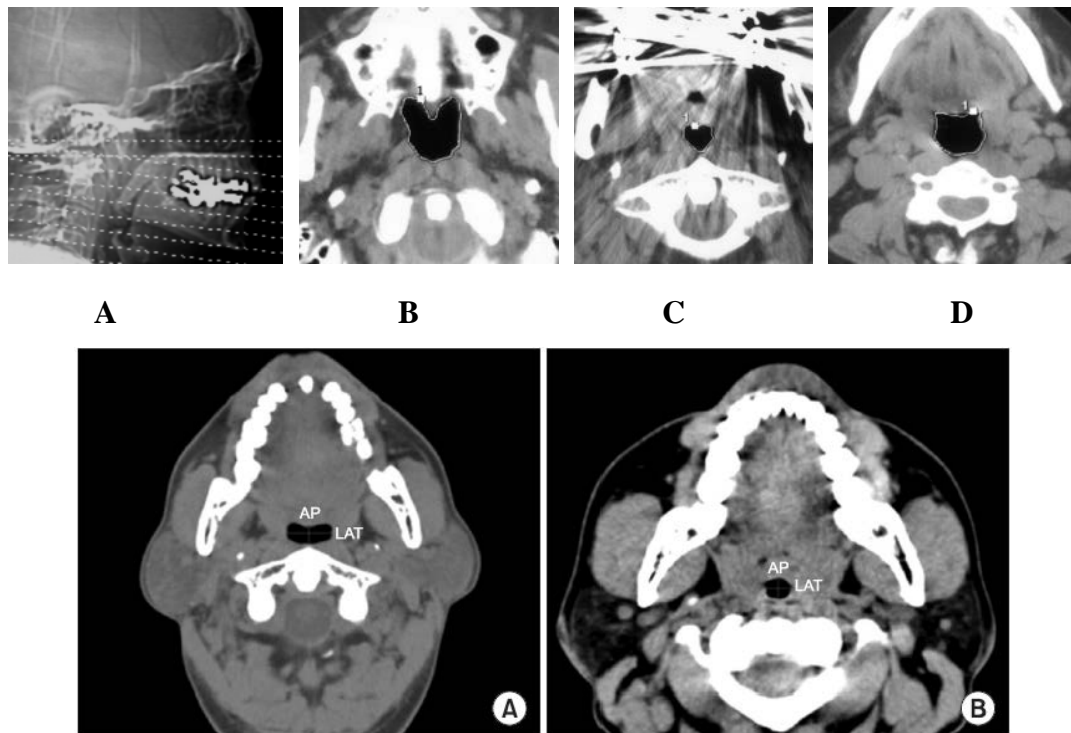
CT Tomography in patient with OSAS. Images show the parameters measured on CT scans. CT was performed to obtain measurements of the luminal area of the airway (outlined areas in B, C and D) at the levels of the nasopharynx, oropharynx, and hypopharynx. (A) Lateral scout view shows the levels (dashed lines) at which CT sections were obtained. CT scans obtained at the (B) hard palate level, (C) oropharyngeal level (20 mm caudal to B), and (D) hypopharyngeal level (50 mm caudal to B). The horizontal computed tomography views show the minimal anteroposterior diameter of the upper airway. A. The ratio of lateral to anteroposterior diameters is more than the 1.5 defined elliptical shape. B. The ratio of lateral to anteroposterior diameters is less than the 1.5 defined ovoid shape. (AP: anteroposterior diameter, LAT: lateral diameter) (*Stuck and Maurer, 2008*).
